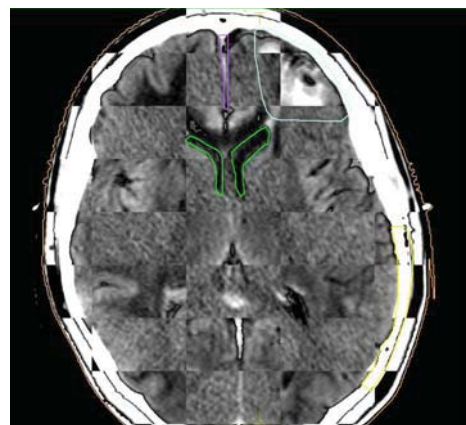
Computed tomography–magnetic resonance imaging (CT-MRI) fusion with delineated falx cerebri (violet line), cornu anterius ventriculi lateralis (green line) and astrocytoma gr. II (blue cyan line)
